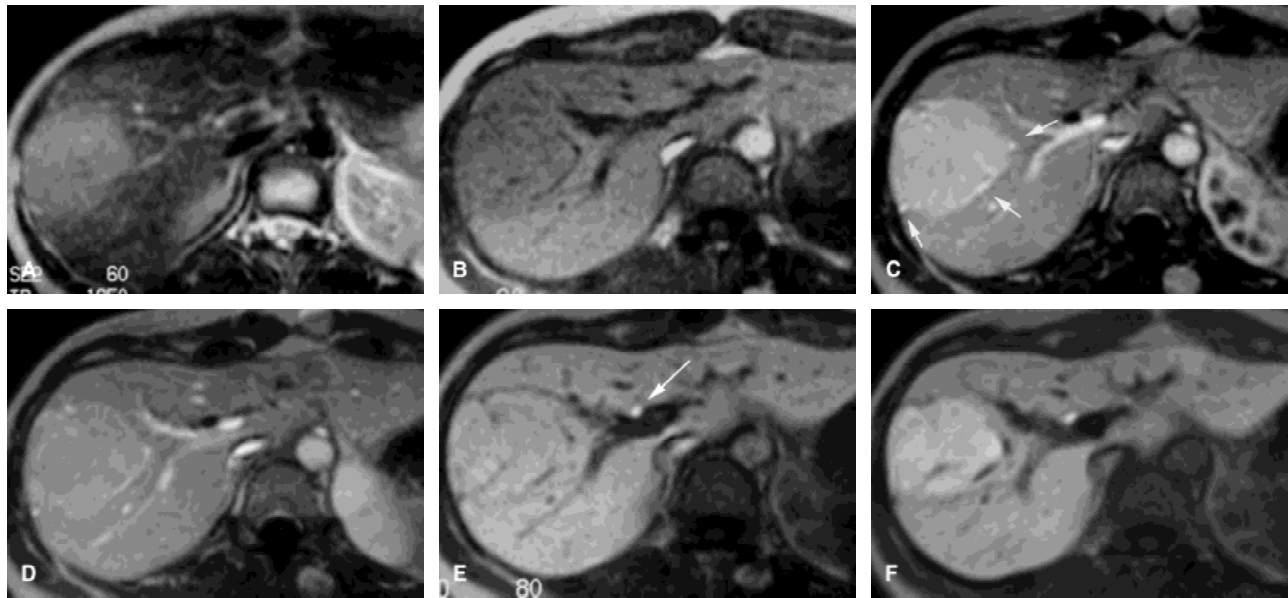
Atypical focal nodular hyperplasia in 34-year-old woman with chronic right upper abdominal pain. a: SE transverse T2-weighted image shows a large homogeneous slightly hyperintense lesion in the right lobe of the liver, without any evidence of central scar. b: GRE transverse T1 precontrast image. The lesion is homogeneously isointense to the surrounding liver parenchyma. During dynamic imaging (GRE transverse T1-weighted), the lesion is homogeneously hyperintense at arterial phase. c: At 25 seconds after bolus administration of Gd-BOPTA, large peripheral feeding vessels are evident (arrows). d: In the portal venous phase obtained 90 seconds after the injection, the lesion persists as slightly hyperintense, but there is no evidence of scar. e: GRE transverse T1-weighted images obtained 2 hours after administration of Gd-BOPTA. There is homogeneous enhancement of the liver, and the lesion appears homogeneously isointense. The main biliary duct is hyperintense due to biliary elimination of Gd-BOPTA (arrow). f: Follow-up after 1 year. GRE transverse T1-weighted images obtained 1 hour after administration of Mn-DPDP. There is homogeneous enhancement of the liver, and the lesion appears markedly hyperintense. No scar is appreciable. With this contrast media the main biliary duct is hyperintense because of biliary elimination.
